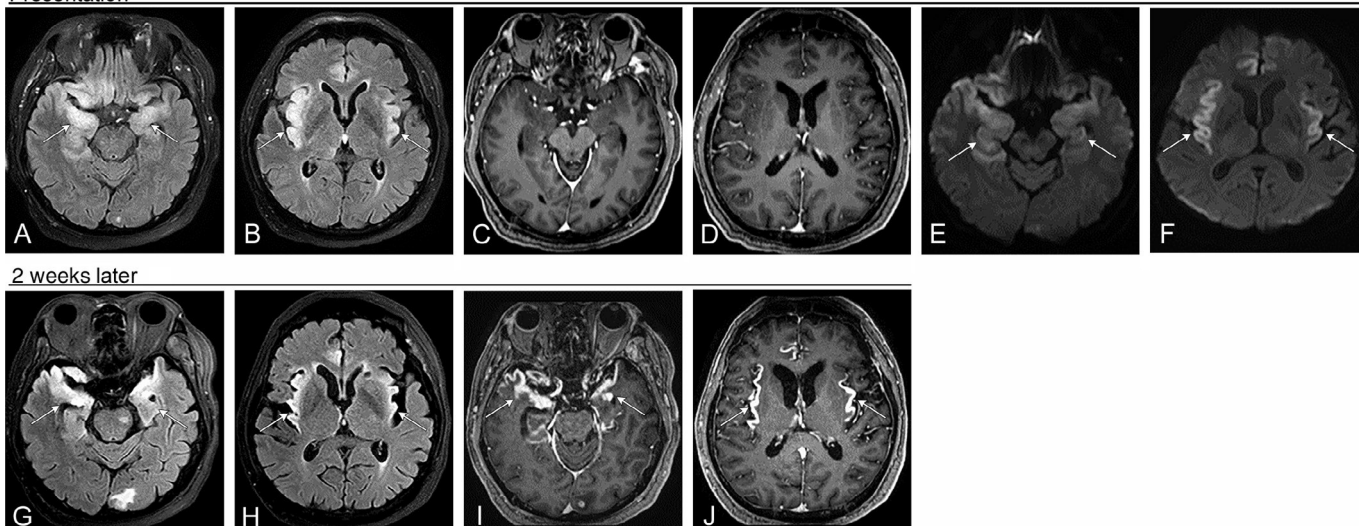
Bilateral herpes simplex encephalitis. Elderly female with history of metastatic lung cancer and known brain metastasis presents with mental status change and seizures. (A and B) FLAIR sequences show bilateral but asymmetric signal in both anterior and medial temporal lobes, both frontal lobes (bilateral orbitofrontal cortex and right gyrus rectus) and both cingulate gyri. There is no associated enhancement (C and D). (E and F) DWI sequences show restricted diffusion in the areas of abnormal FLAIR signal, confined to the cortex. Two weeks later, FLAIR signal persists (G and H). (I and J) However, there is now intense cortical enhancement corresponding to the areas of FLAIR hyperintensity. Signal abnormality in the left occipital lobe and left pons is secondary to treated metastatic disease.
